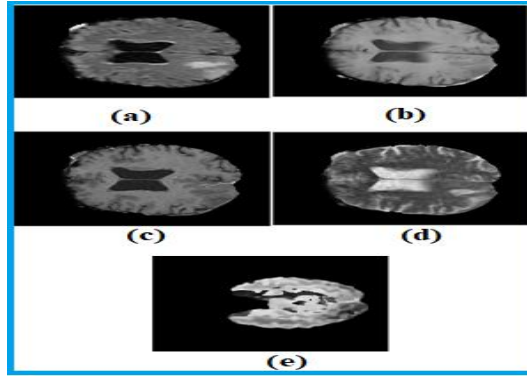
Brain MRI Modalities a. *Flair* b. *T1* c. *T1C* d. *T2* e. *T1GD*
